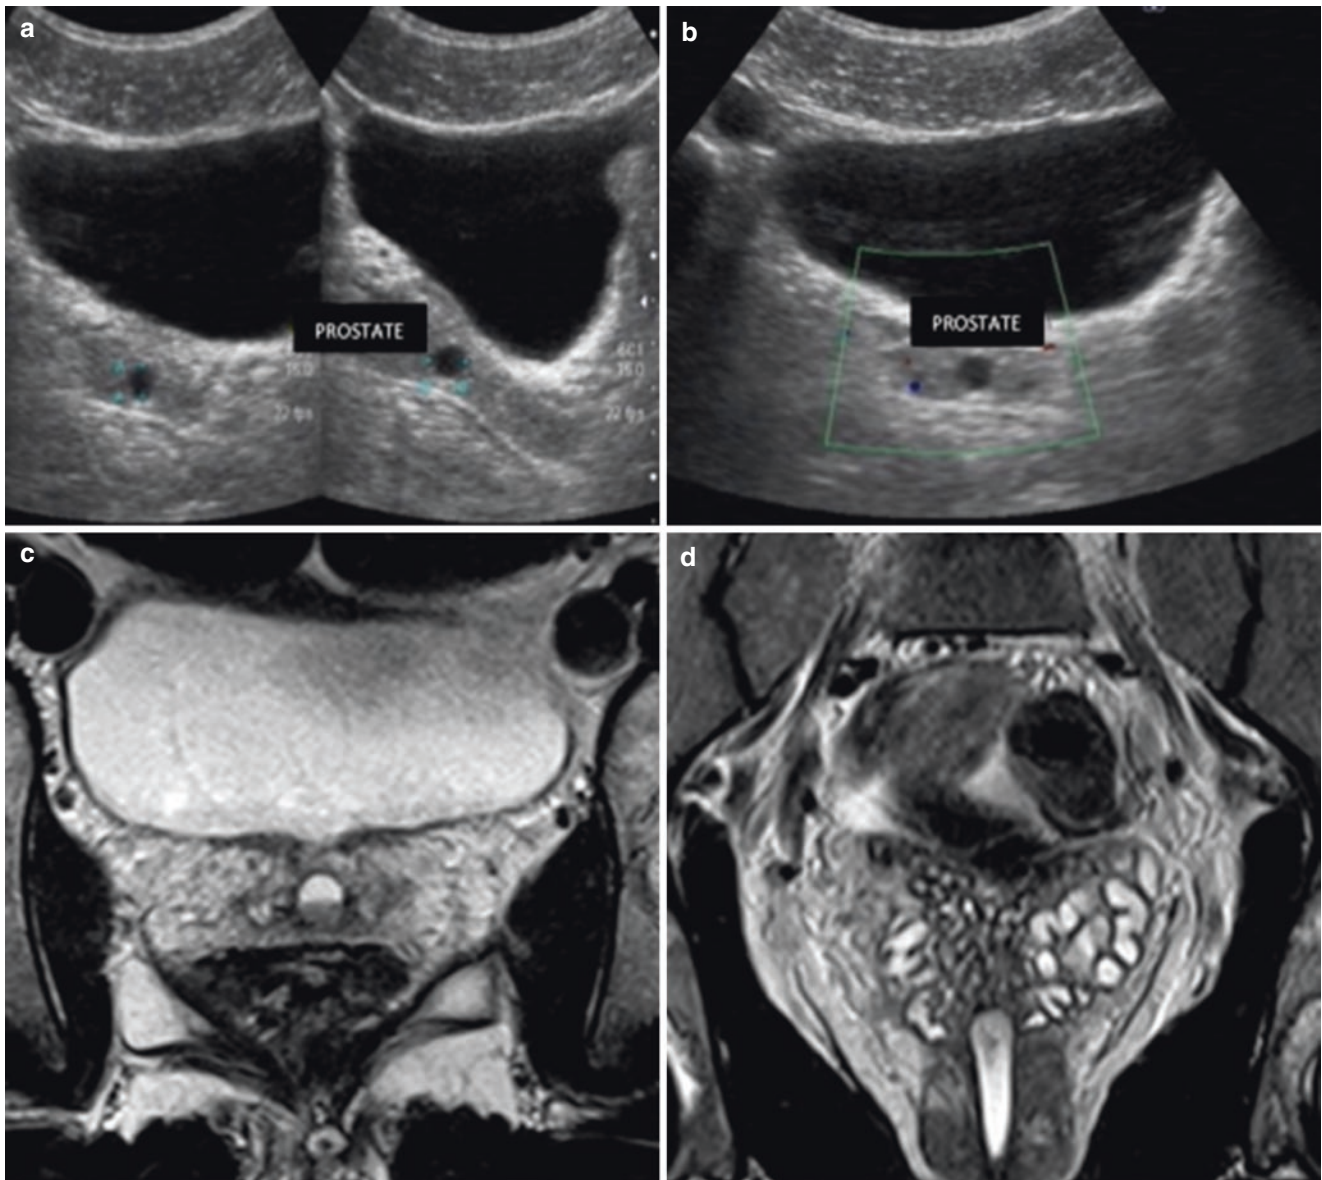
Prostatic utricle cyst in a 30-year-old man with hematospermia. Transabdominal US (a,b) shows a small midline prostatic utricle cyst anechoic at US. Axial (c) and coronal (d) T2-weighted MR images
